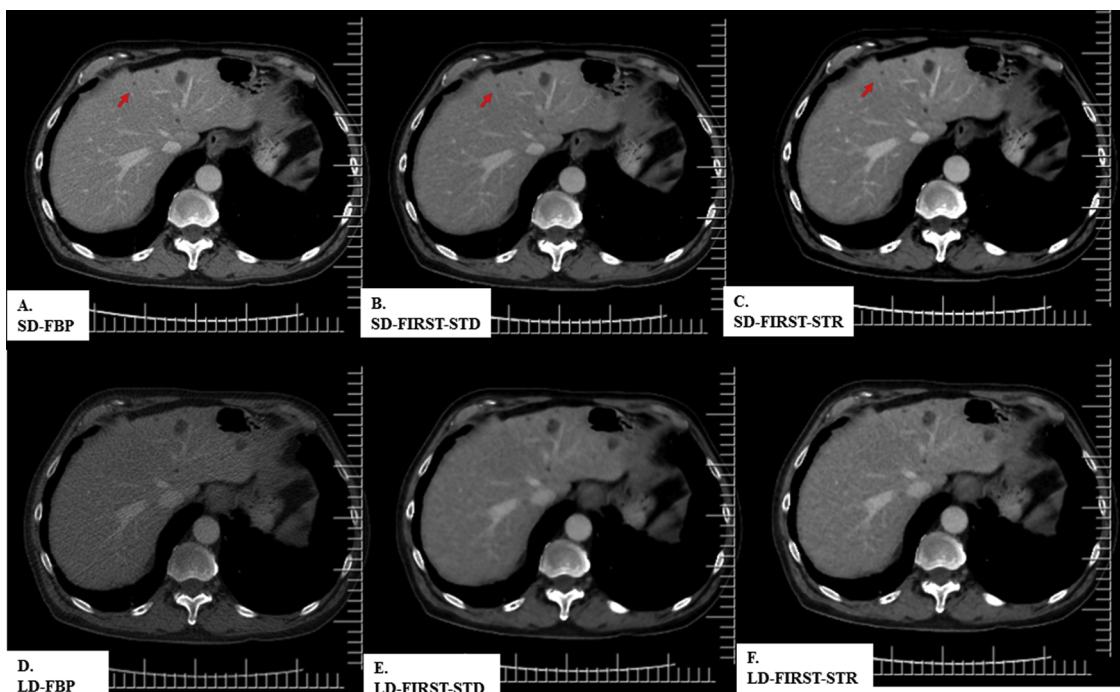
A 62-year-old man (BMI 23 kg/m²) underwent contrast-enhanced CT of the abdomen at SDCT (CTDIvol 11 mGy) and LDCT (2.8 mGy) images. All SDCT images demonstrate low attenuation hepatic lesions likely cysts in right hepatic lobe. LDCT images detected all lesions except a small cyst (arrow).
